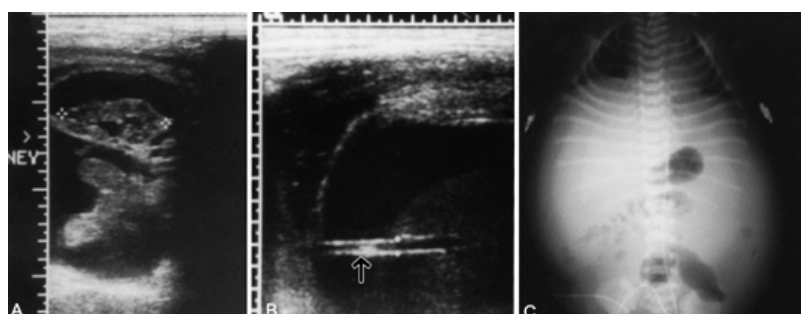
Urinary ascites secondary to posterior urethral valves. A: Prenatal ultrasound, 38 weeks of gestation, showing right kidney and ascites. B: Massive ascites, resulting in stretching of umbilical vein (*arrow*). L, liver. C: Abdominal film at birth, showing characteristic appearance of ascites. Note umbilical artery catheter.
